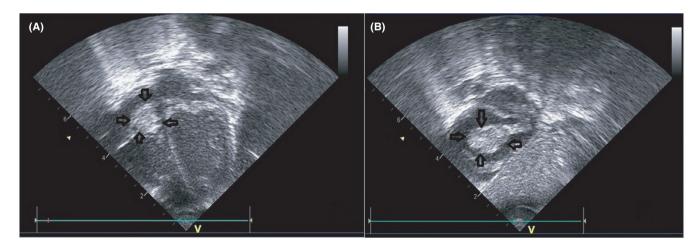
A and B, Transthoracic echocardiography. Mass in the right atrium (black arrow)
